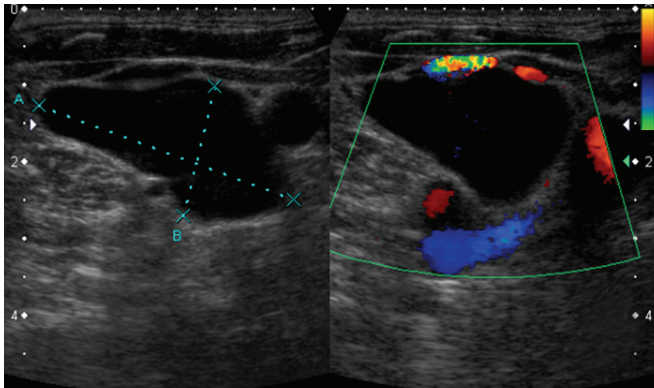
Ultrasound neck-cystic avascular lesion
